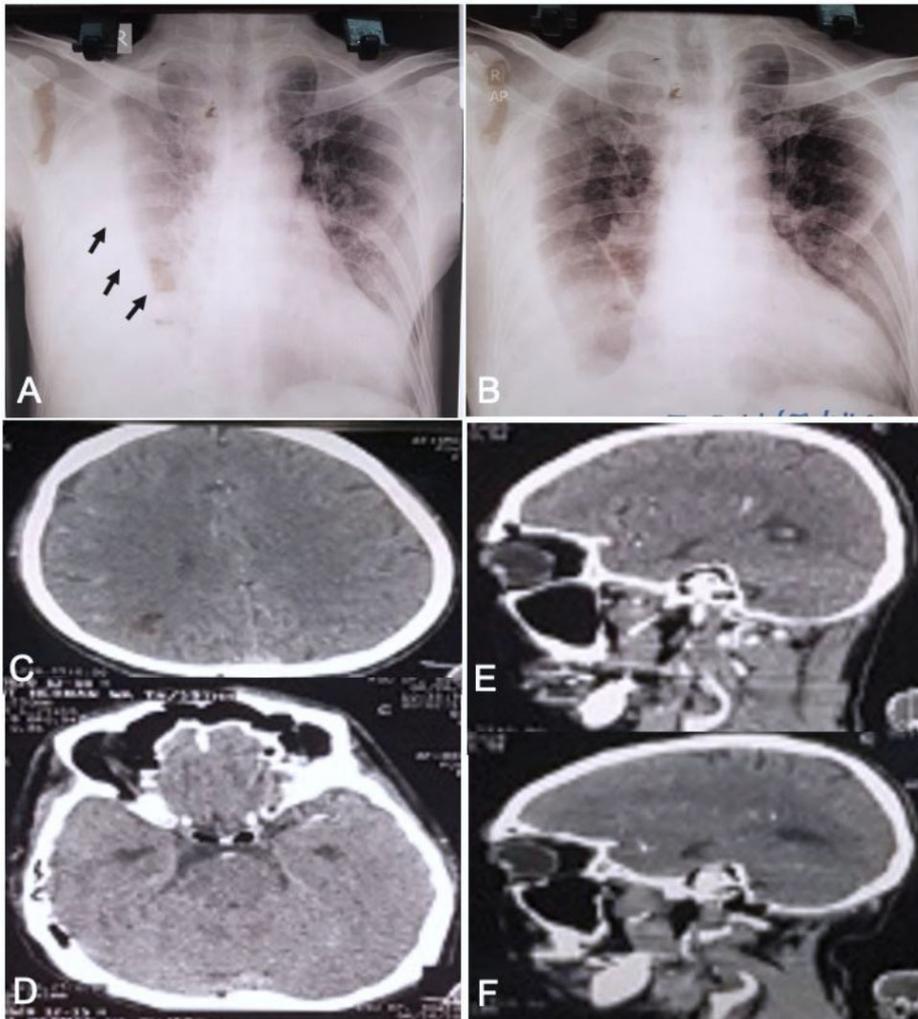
Chest radiograph and head CT-scan of the patient. (A) Chest radiograph showing homogenous opacity in right laterobasal hemithorax prior to fluid evacuation suggesting pleural effusion (black arrows). (B) Chest radiograph showing homogenous opacity in right laterobasal hemithorax shadowing the right costophrenic sinus, fibroinfiltrate in the left and right suprahilar post-evacuation of 1000 ml. (C-F) showing the normal head CT-scan.
